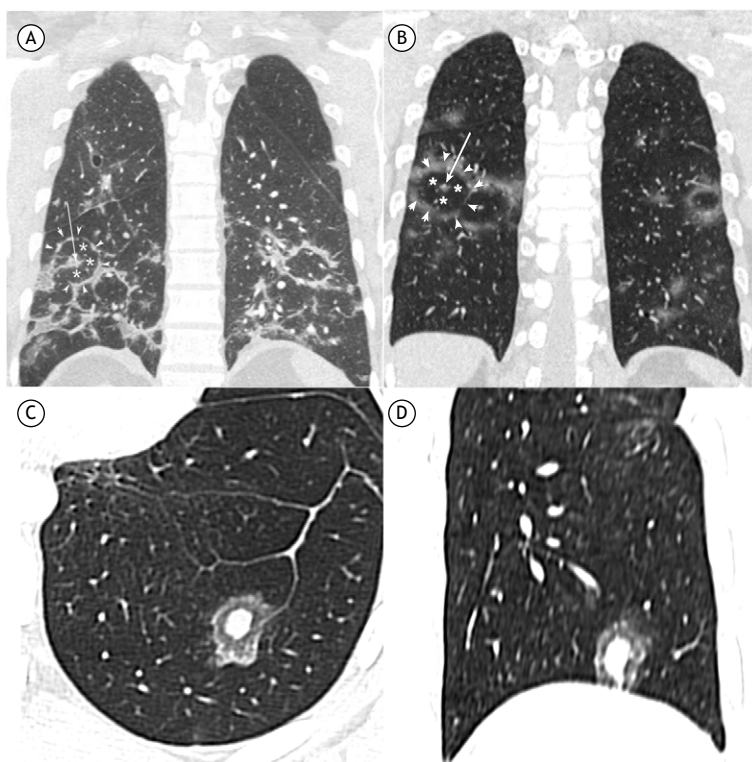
In A and B, coronal CT scans of two different patients with confirmed COVID-19, showing perilobular opacities and imaging findings consistent with the target sign, including central nodular opacity (arrows), a dense peripheral rim (arrowheads), and an inner ring suggestive of normal lung parenchyma (asterisks). In C and D, chest CT scans of a patient with pulmonary osteosarcoma metastasis, showing similar imaging findings, including central nodular opacity surrounded by two concentric ring-like opacities of low density.
